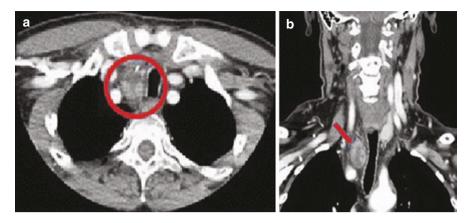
Contrast CT scan (a) Transverse view demonstrating parathyroid gland with possible tracheal invasion (red circle); (b) Coronal view suggesting possible tracheal involvement by parathyroid mass (red arrow)
